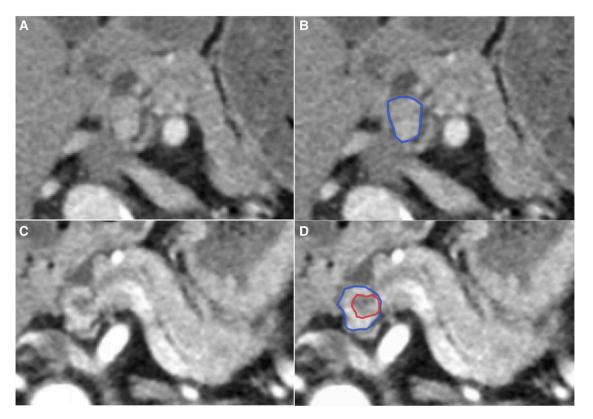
Computed tomography scans show (A) the tumor before radiofrequency ablation (RFA); (B) margins of the tumor in blue before RFA; (C) tumor after RFA; (D) margins of the tumor in blue and margins of the ablated zone in red after RFA.
